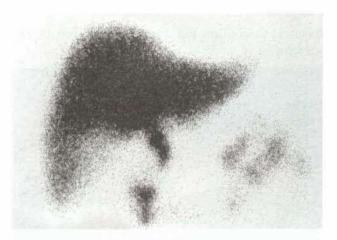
HIDA scan showing nonvisualisation of gall bladder—a case of acute cholecystitis (CT is more specific)
